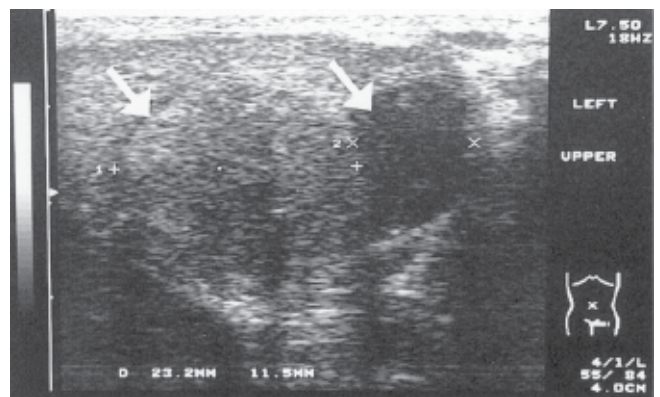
Ultrasound of the left scrotum, upper pole (transverse). Image shows 2 solid nodules of different echogenicity adjacent to the testis (arrows).
